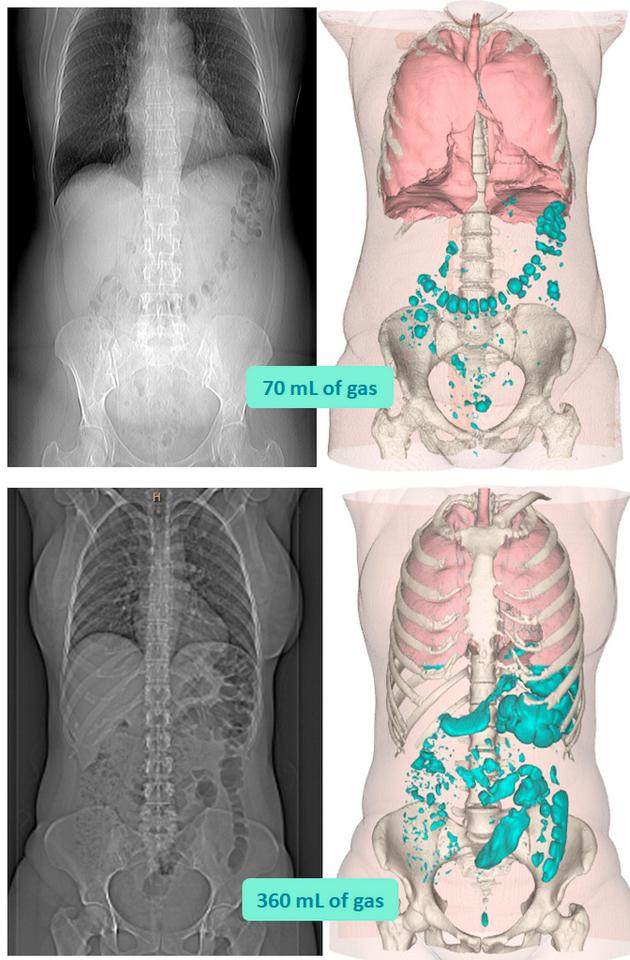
Examples of abdominal CT scans and scout views as plain AP projections in two patients. Images contain 70ml (A) and, (360ml gas measured by volumetric analysis, respectively
